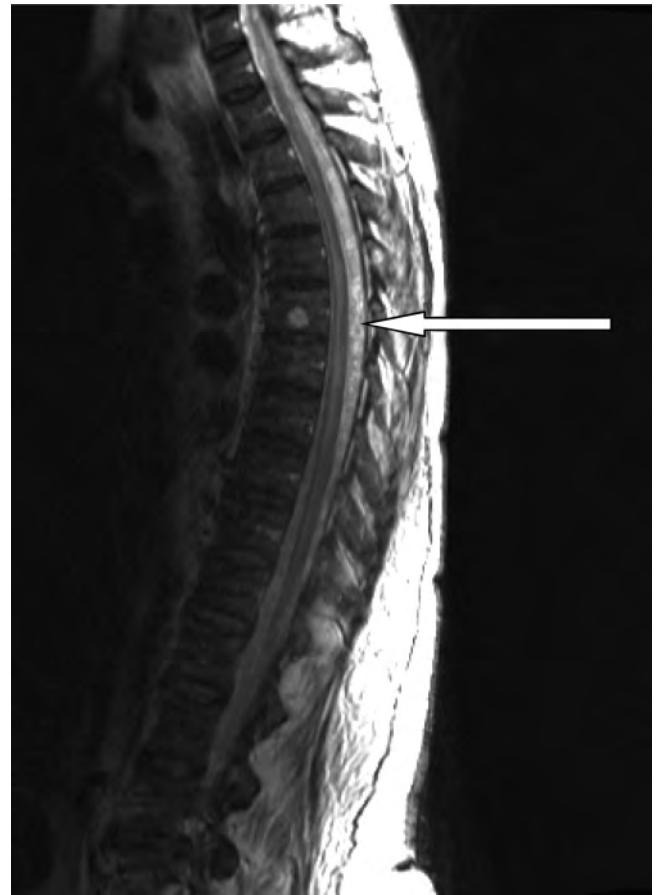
Extensive posterior epidural abscess (MRI T2W) (arrow).
